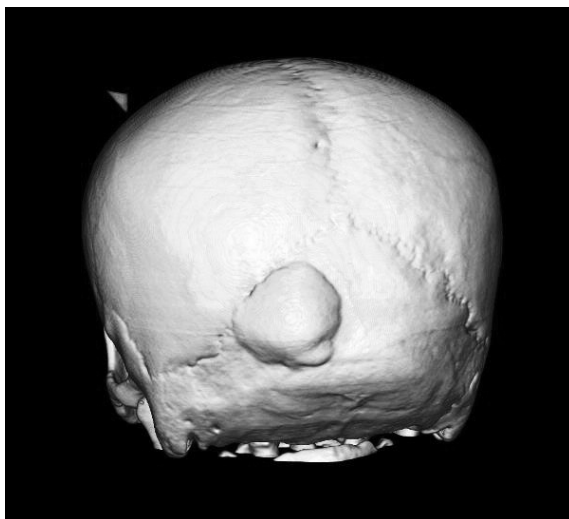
A bony mass of was revealed in 3 dimensional CT.
